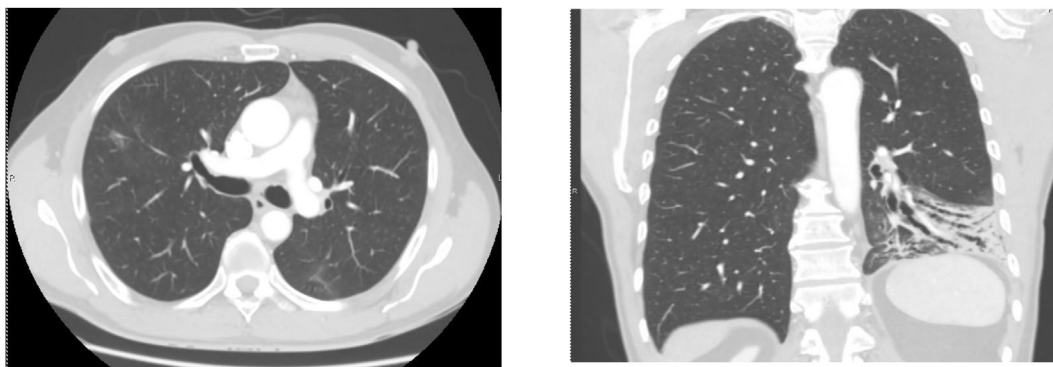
A, B: Axial and coronal views respectively. Third CT scan 3 months after chemotherapy, showing significant radiological improvement of the previously described opacities.
